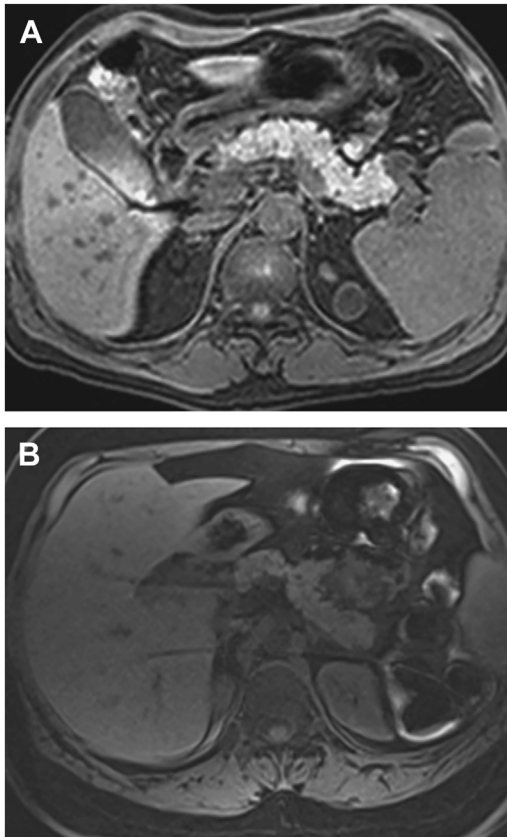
MRI with normal and abnormal T1 signals. (A) Contrast-enhanced MRI showing uniformly homogenous and normal T1 signal. (B) Contrast-enhanced MRI showing decreased T1 signal in chronic pancreatitis.
